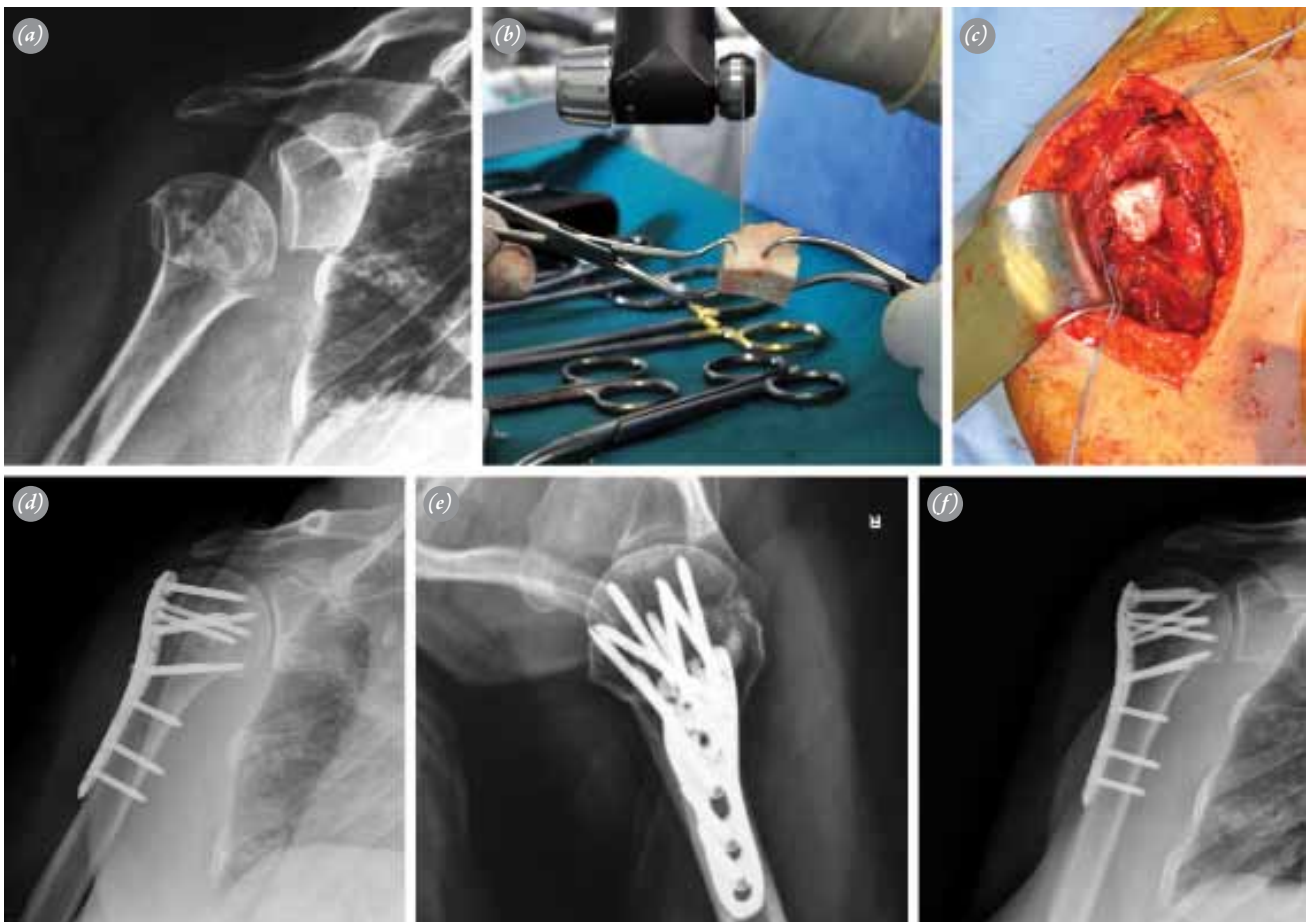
(a) 70-year-old patient (Pat. No. 7), referred with a valgus-impacted proximal humerus fracture. (b) Allograft being prepared to fit the cavity under the head. (c) Graft placed before instrumentation. (d, e) Early postoperative X-rays; graft is visible below head. (f) Follow-up at 1 year postoperatively, graft united successfully without any collapse. [Color figures can be viewed in the online issue, which is available at www.aott.org.tr]
